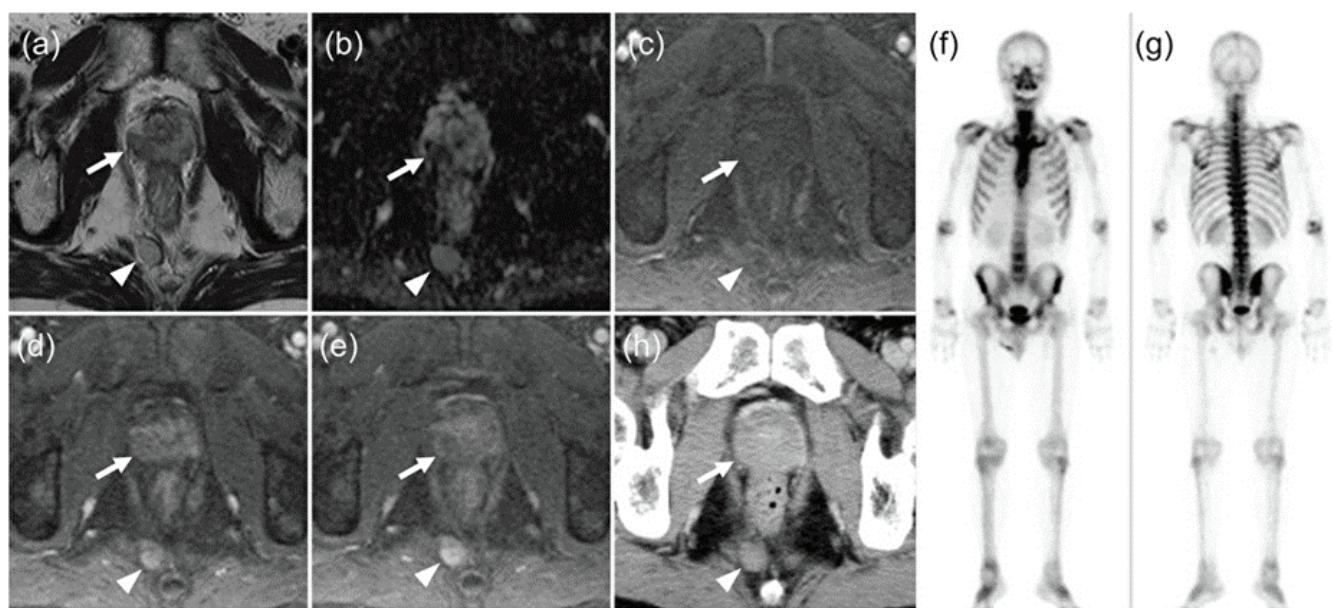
Magnetic resonance imaging, CT, and Tc-99m methylene diphosphonate bone scintigraphy. (a) Axial T2-weighted turbo spin-echo image reveals a hypointense lesion (arrow) within the right peripheral zone in the mid gland, exhibiting capsular invasion. The presacral nodule (arrowhead) exhibits higher signal intensity compared to that of the skeletal muscle; (b) The apparent diffusion coefficient map generated from diffusion-weighted imaging revealed a hypointense lesion (arrow) in the right peripheral zone and an intermediate signal intensity lesion (arrowhead) in the right presacral area. The signal intensity of the presacral nodule is higher than that of the prostate lesion; (c) Axial precontrast fat-suppressed T1-weighted image. Both the prostate lesion (arrow) and presacral nodule (arrowhead) are not detectable; (d) Arterial phase T1-weighted postcontrast image demonstrates mild heterogeneous enhancement (arrow) of the tumor in the right peripheral zone. The presacral nodule exhibited homogeneous enhancement (arrowhead); (e) Venous phase T1-weighted postcontrast image demonstrates washout (arrow) of the tumor. The presacral nodule showed marked and persistent enhancement without washout (arrowhead); (f,g) Whole-body bone scintigraphy using Technetium-99m methylene diphosphonate revealed no osteoblastic metastasis. (f) anterior. (g) posterior; (h) Portal venous phase contrast-enhanced CT demonstrated a well-demarcated presacral nodule (arrowhead) that is suggestive of lymph node metastasis. The tumor located in the right peripheral zone is barely discernible (arrow).
